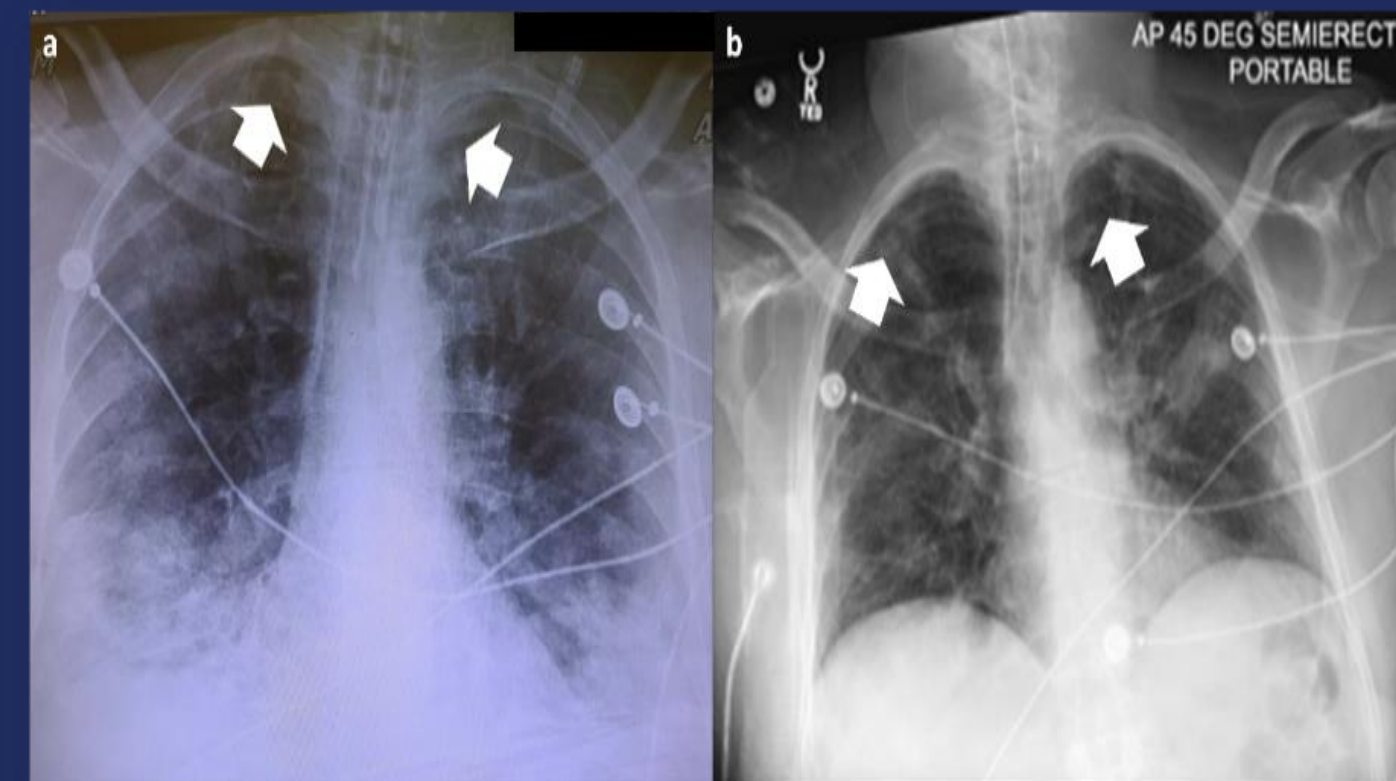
a. Chest X-ray from Day 13 displayed progression of confluent ground-glass consolidative opacities involving the lung bases and involvement of the periphery of the upper lobes bilaterally (arrows). b. Chest X-ray from Day 24 display persistent bilateral patchy pulmonary infiltrates with somewhat interim improved pulmonary ventilation (arrows). *Courtesy of M. Ismail, MD.*
